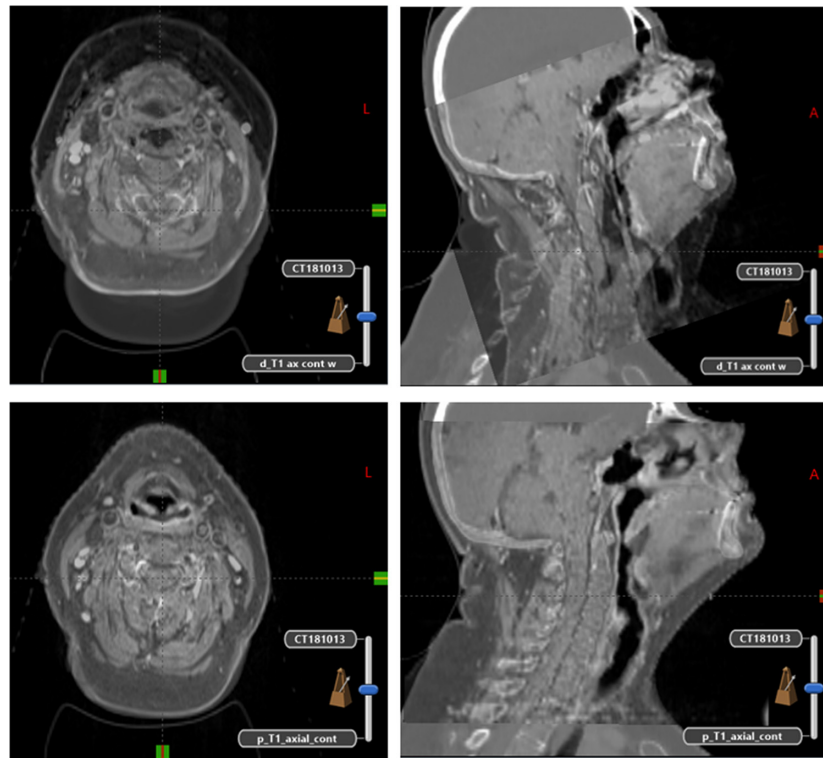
dMRI / CT registration (A) versus pMRI/CT registration (B)
